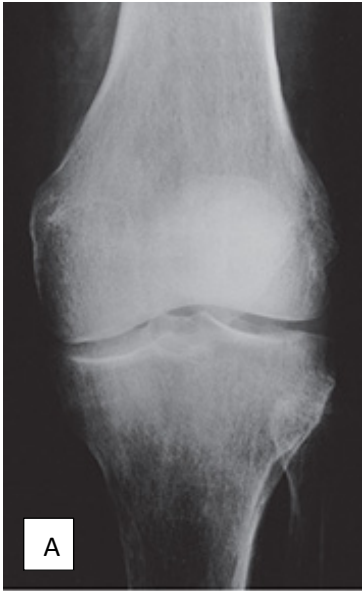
Anteroposterior (A) and lateral (B) radiographs of the knee show increased radiolucency of bones, thinning of the cortices, and sparse trabecular pattern. These changes are more effectively demonstrated on axial computed tomography sections obtained through the proximal tibia and fibula (C) and distal femur (D), as well as on the reformatted coronal image of the distal femur (E). (Reprinted with permission of the Authors and Publisher from Greenspan A, Beltran J. Orthopaedic imaging – A practical approach. 7th ed., Philadelphia 2021, Wolters Kluwer, figure 27.2, p.1285).
